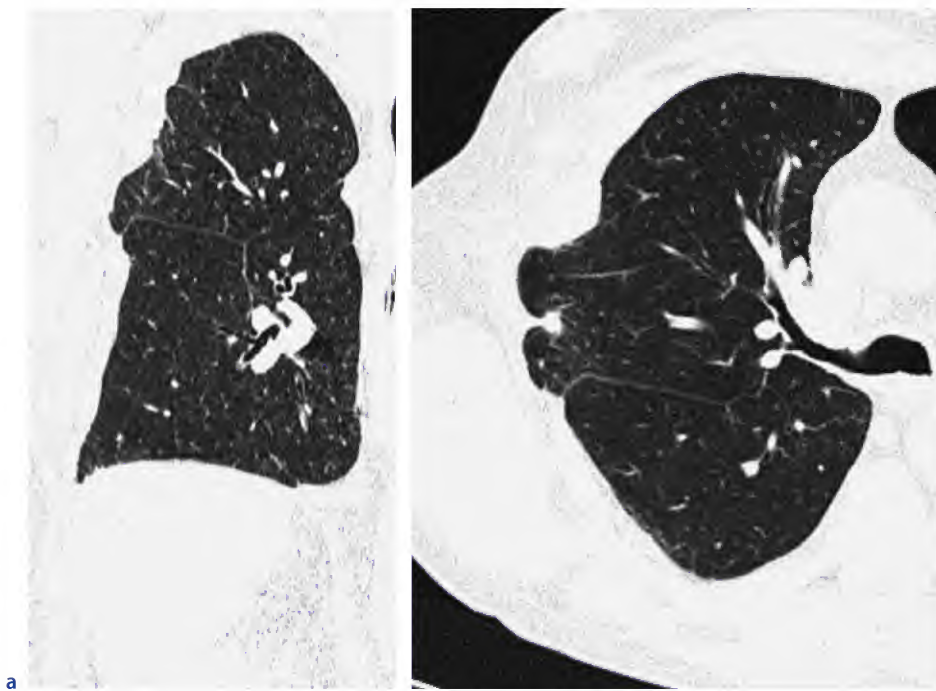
Coronal multiplanar reconstructed CT section of left lung. CT section shows a postbiopsy nodule
